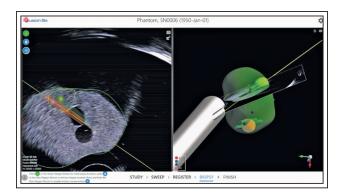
Fusion Bx biopsy view; showing on the left is the live ultrasound view with the contour and lesion overlay, and on the right is the 3D model of the prostate and lesions in relation to the ultrasound probe.
